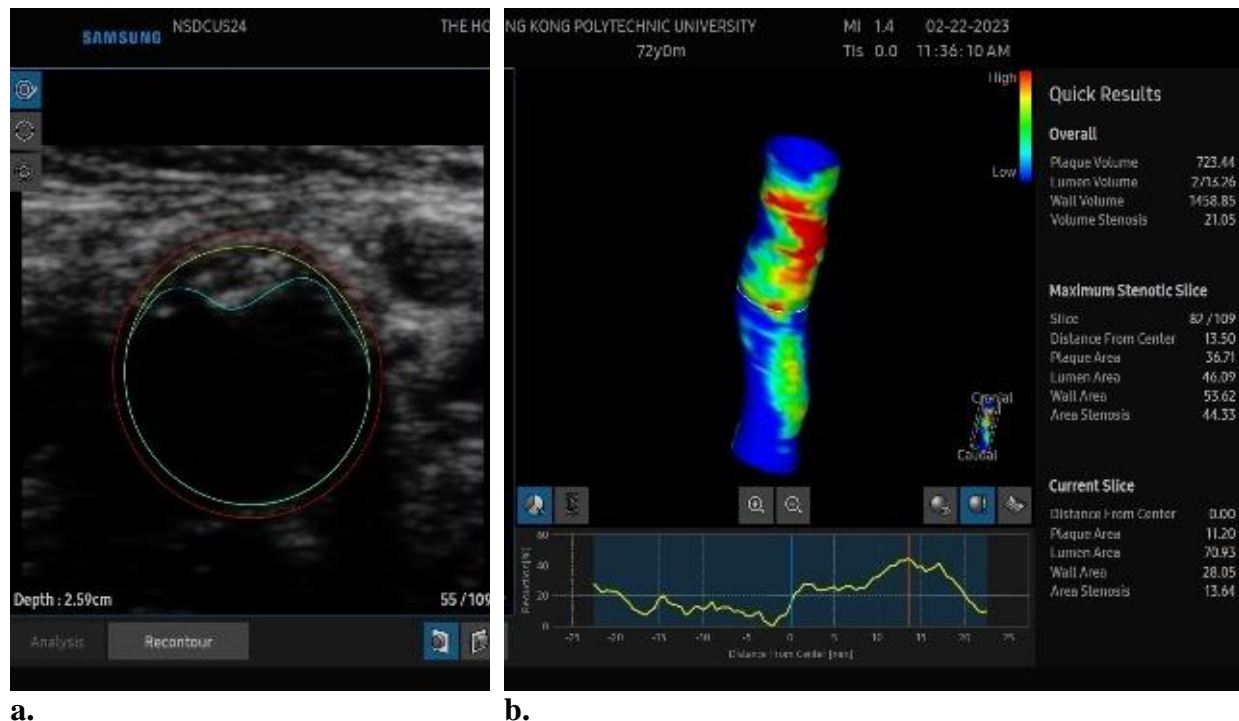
Images showing 3D volumetric assessment of carotid artery stenosis using automated arterial analysis software on Samsung RS85 ultrasound machine. (a) is a transverse section demonstrating a plaque and (b) 3D acquisition image showing the more vulnerable areas depicted by the red color. Adapted from: own images Hong Kong Polytechnic University ultrasound lab, (2022).
